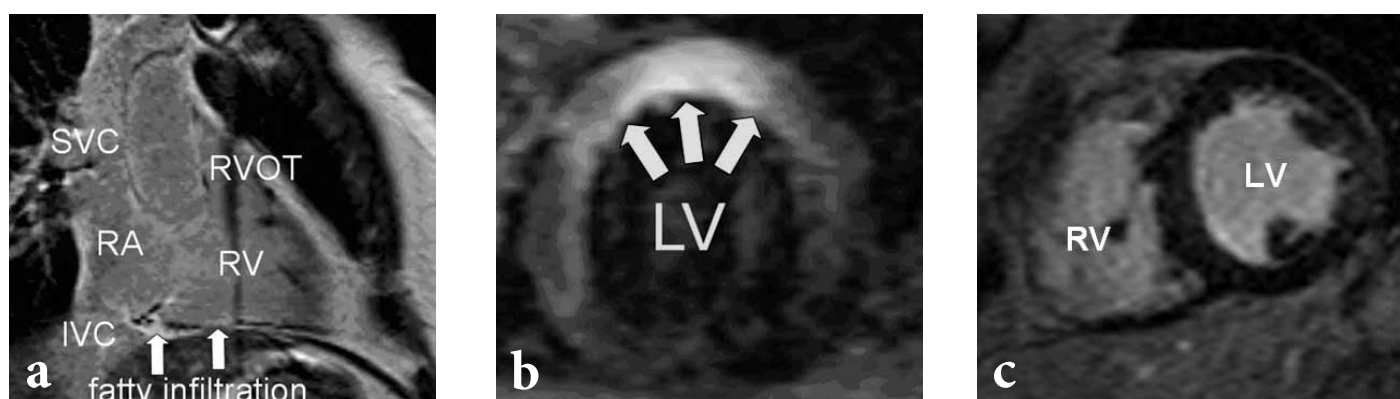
CMR provides information on tissue characteristics: (a) fatty infiltration in a patient with arrhythmogenic right ventricular dysplasia; (b) myocardial oedema of the anterior left ventricular wall in a patient with viral myocarditis (T2-weighted sequence); (c) intra-myocardial iron deposits appear dark compared with normal myocardium on T2* images. LV = left ventricle; RV = right ventricle; SVC = superior vena cava; IVC = inferior vena cava; RVOT = right ventricular outflow tract. Images (a) and (b) courtesy of Dr Jan-Peter Smedema.
